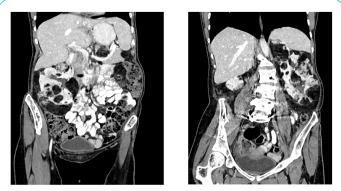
Case 2-CT images before everolimus therapy. Renal angiomyolipomas with a diameter of 20 cm and destructing the renal parenchyma.
